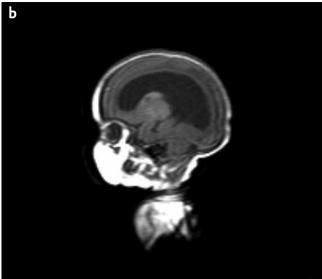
a, b. Polymicrogyria and ventricular enlargement on brain magnetic resonance imaging of the patient
